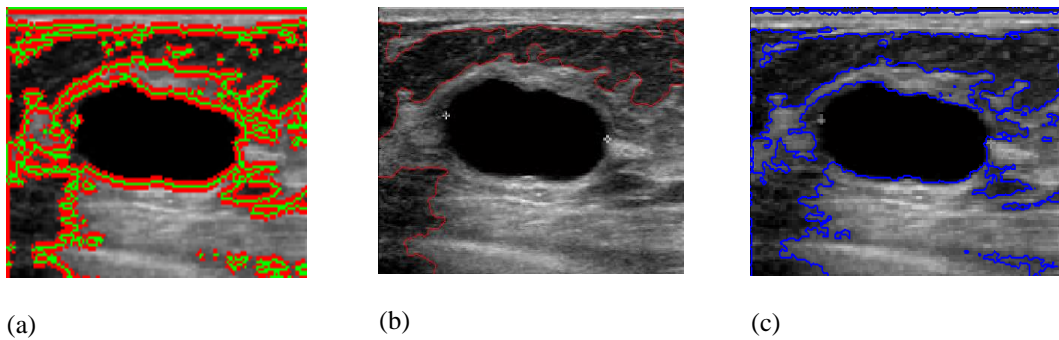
Experiments on ultrasound image of breast cysts. The final results using the C-V, SGLACM, and proposed methods are shown in the first, second, and third columns, respectively. The parameter of $\alpha=0.1$ and $\sigma = 5$.
